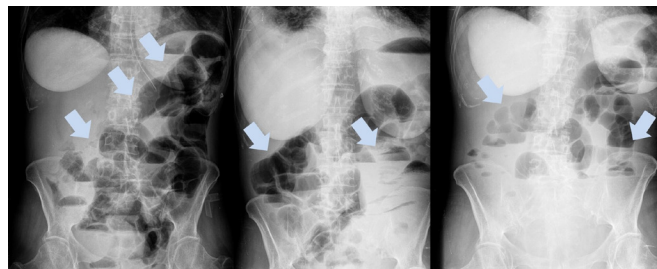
Serial abdominal radiographs of the patient during flares of abdominal pain and bloating, revealing exuberant distension of bowel loops with air-water levels (arrows).
